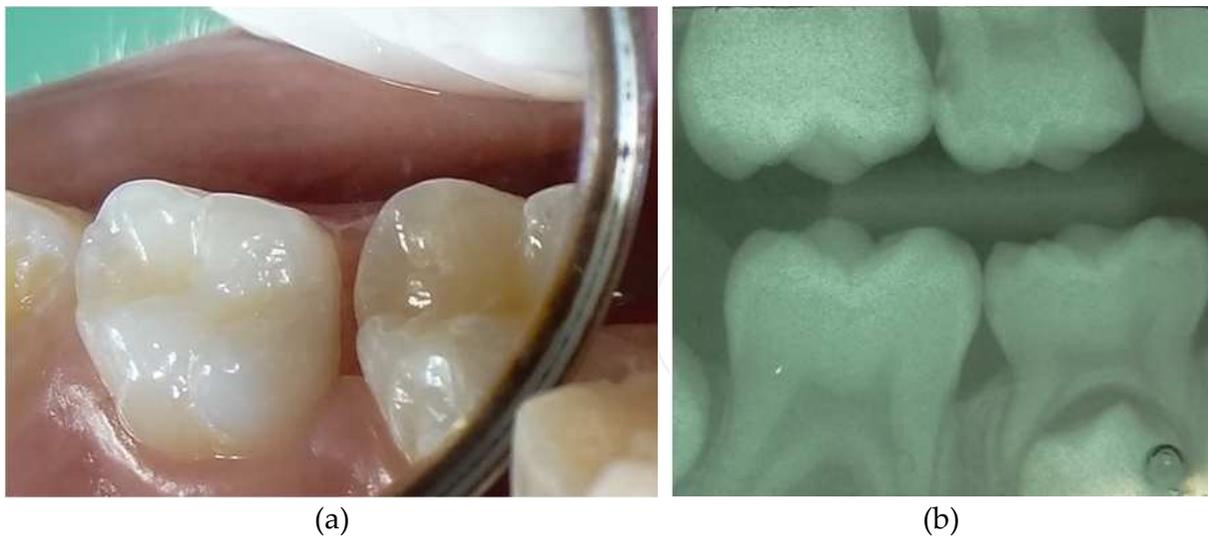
Direct visual inspection (a) and radiograph (b) of the same surface (distal surface of the second primary molar). Clinically, we can see a white spot on the approximal surface (absence of shadows in the marginal bridge) – (a). Radiographically, we evidence a radiolucid image suggestive of caries lesion in dentine. The image might also suggest the presence of cavity (b), that is definitely not evidenced in clinical examination (a). This case represents a false-positive result for caries in dentine that could occur in some radiographic examinations.
